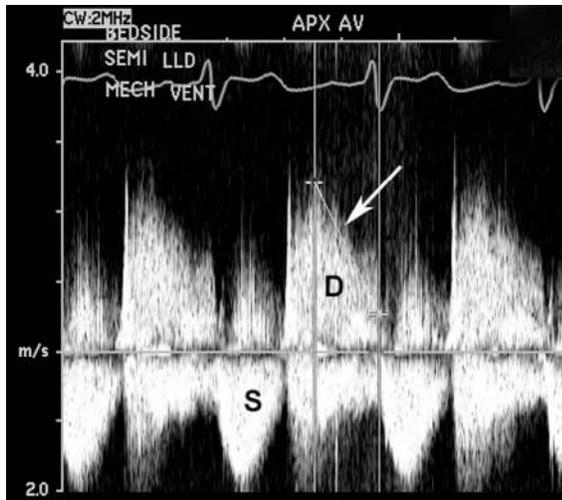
Same patient as Fig. 76.6. Continuous-wave Doppler recording of flow across the aortic valve shows an increased antegrade velocity in systole (S) consistent with a high transaortic stroke volume. In diastole (D), a dense signal of retrograde flow is seen, with a steep deceleration slope (arrow) consistent with rapid equalization of pressures between the aorta and left ventricle in diastole from acute regurgitation.
